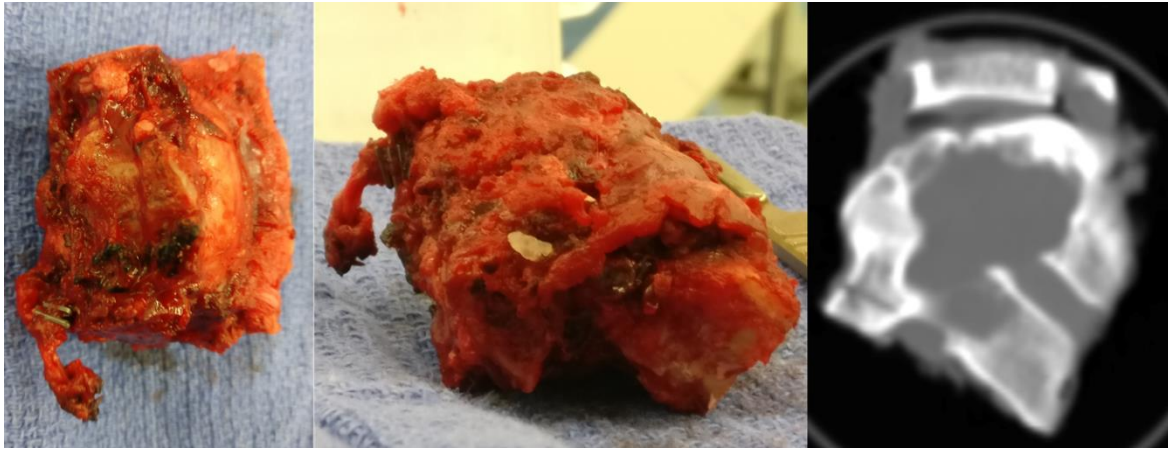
Post excision photographs and radiograph of the excised tumours showing no macroscopic breach. Vascular clips are visible on vertebral artery V2
